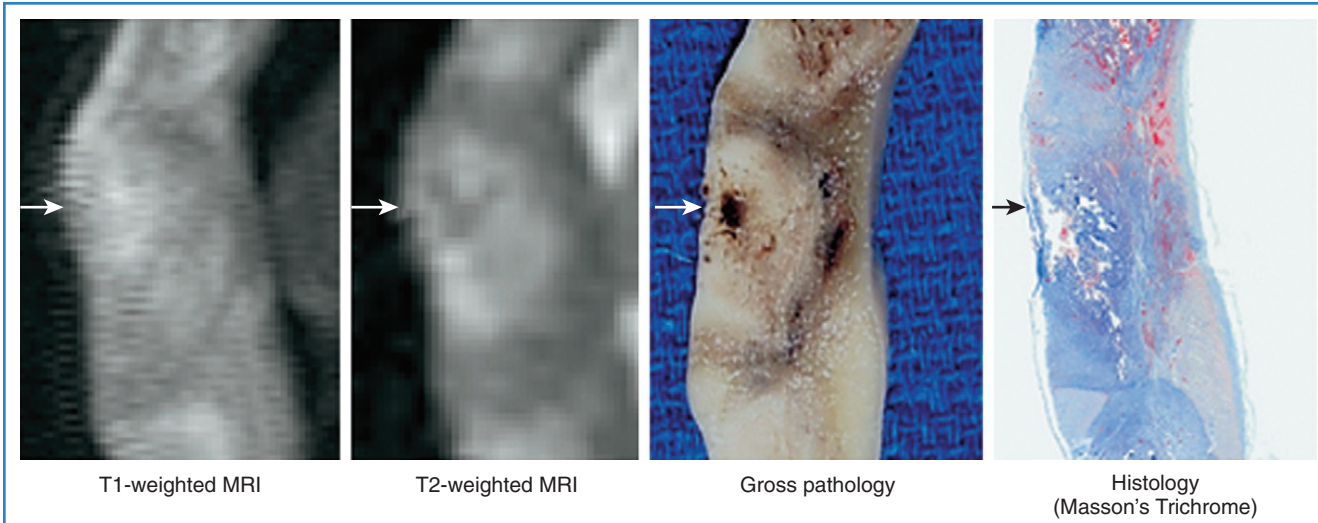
Assessment of intra-lesional pathology. Visualization of intra-lesional necrotic cavities of high-energy lesions as areas of low and high signal intensity when using T2- and T1-weighted imaging, respectively. *MRI*, Magnetic resonance imaging.
